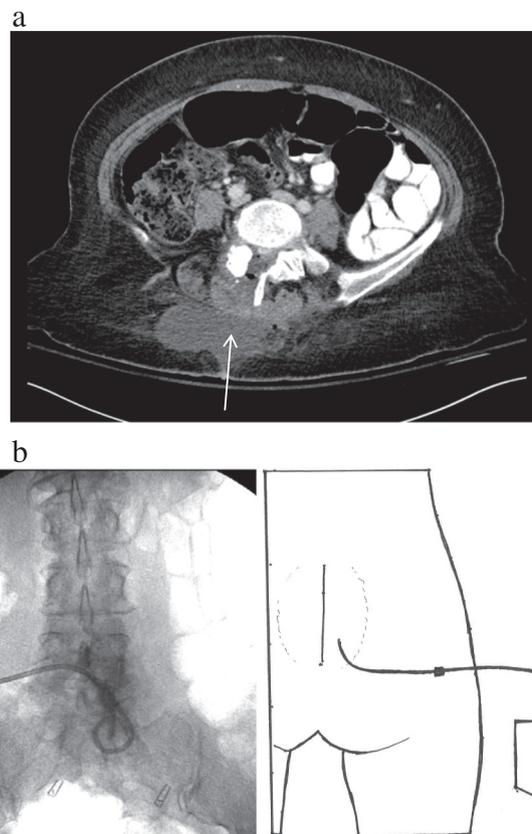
a: Axial CT image. Arrow highlights fluid collection. b.
